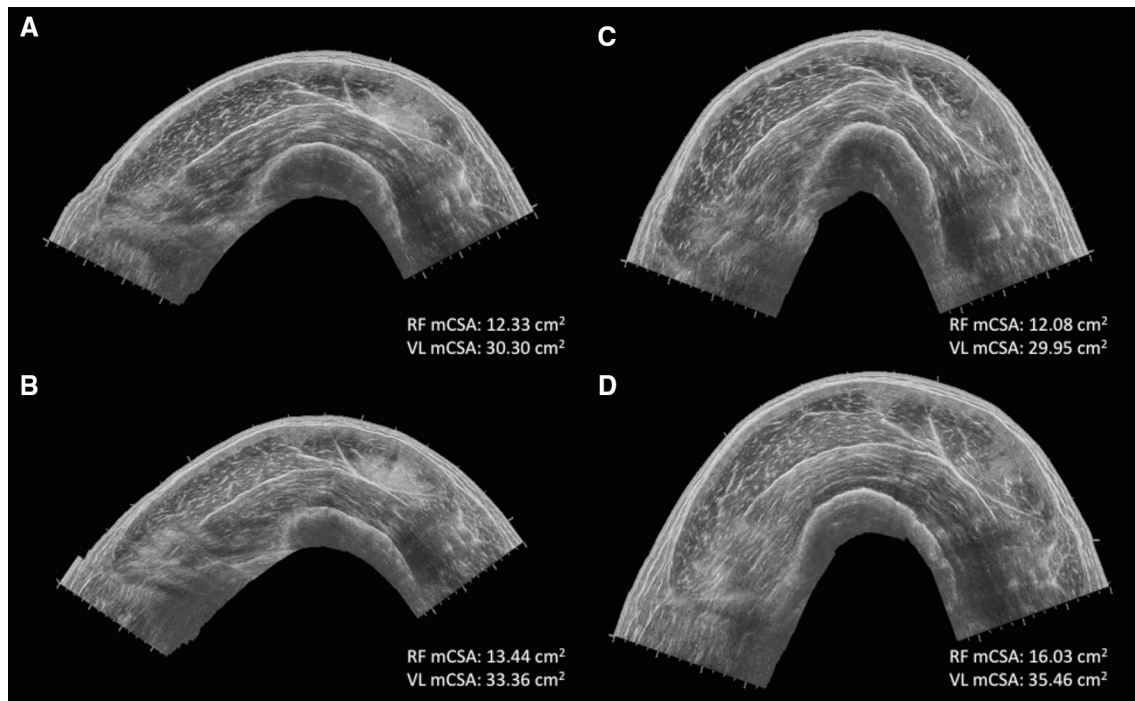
Example of panoramic ultrasound scans a pre- and b post-exercise at 80 % 1RM and c pre- and d post-exercise at 30 % 1RM
